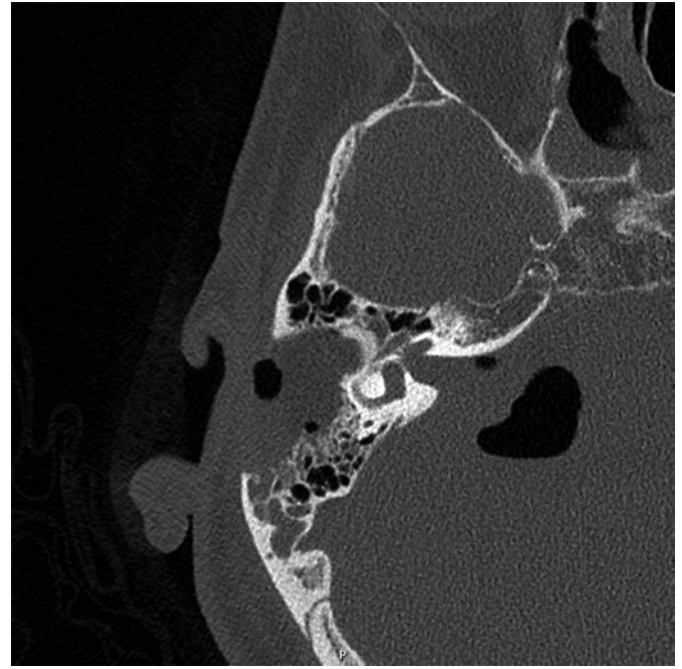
Postoperative CT imaging showing resolving pneumocephalus.
